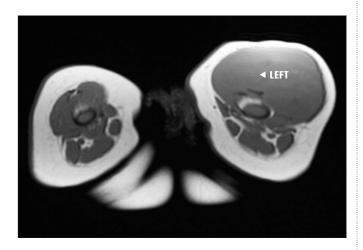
MRI showing mass in left thigh muscle.
